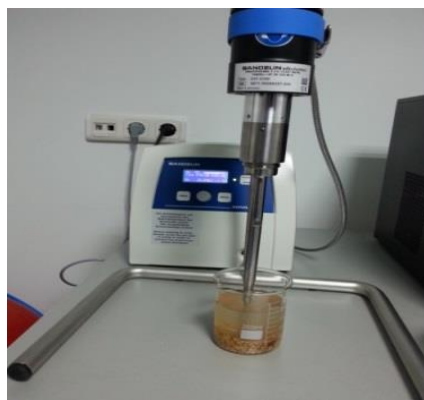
Ultrasonic device and probe system used in the experiments
